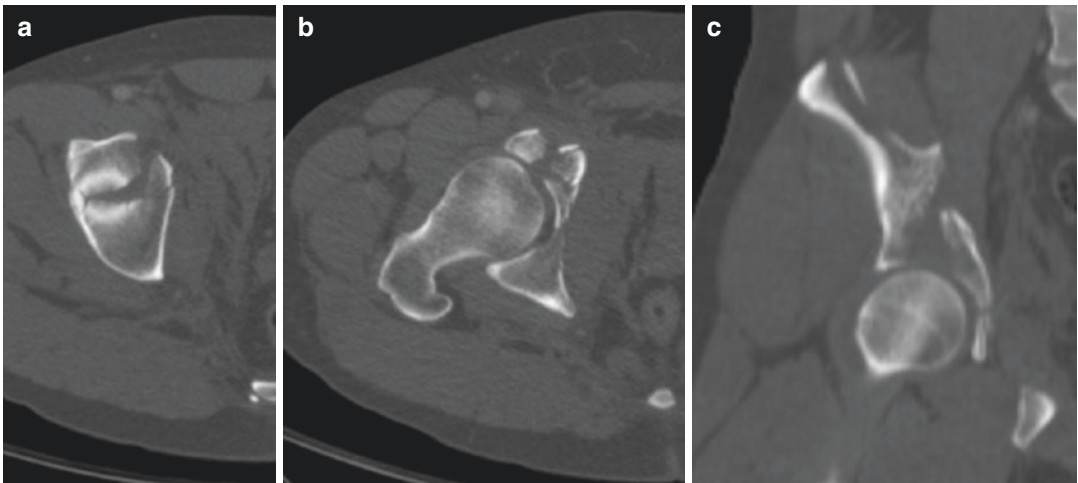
Pre-operative CT scan of the same patient. Axial (a, b) and coronal (c) planes of the fractured acetabulum.
